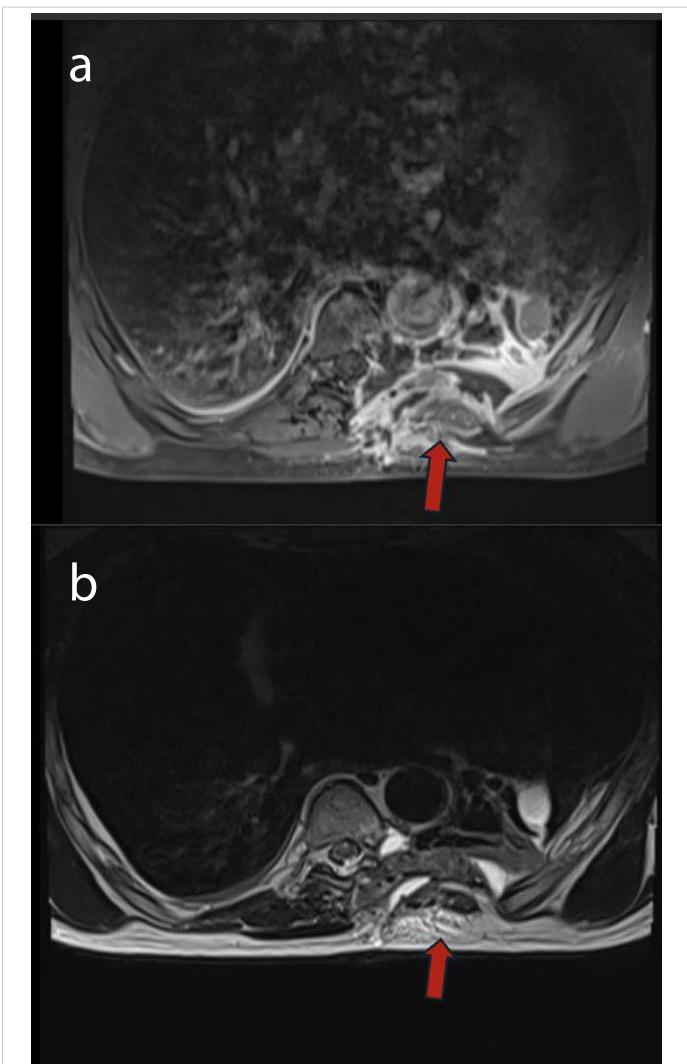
a(T1): The MRI showing a mass lesion. b(T2): The MRI showing a mass lesion.
